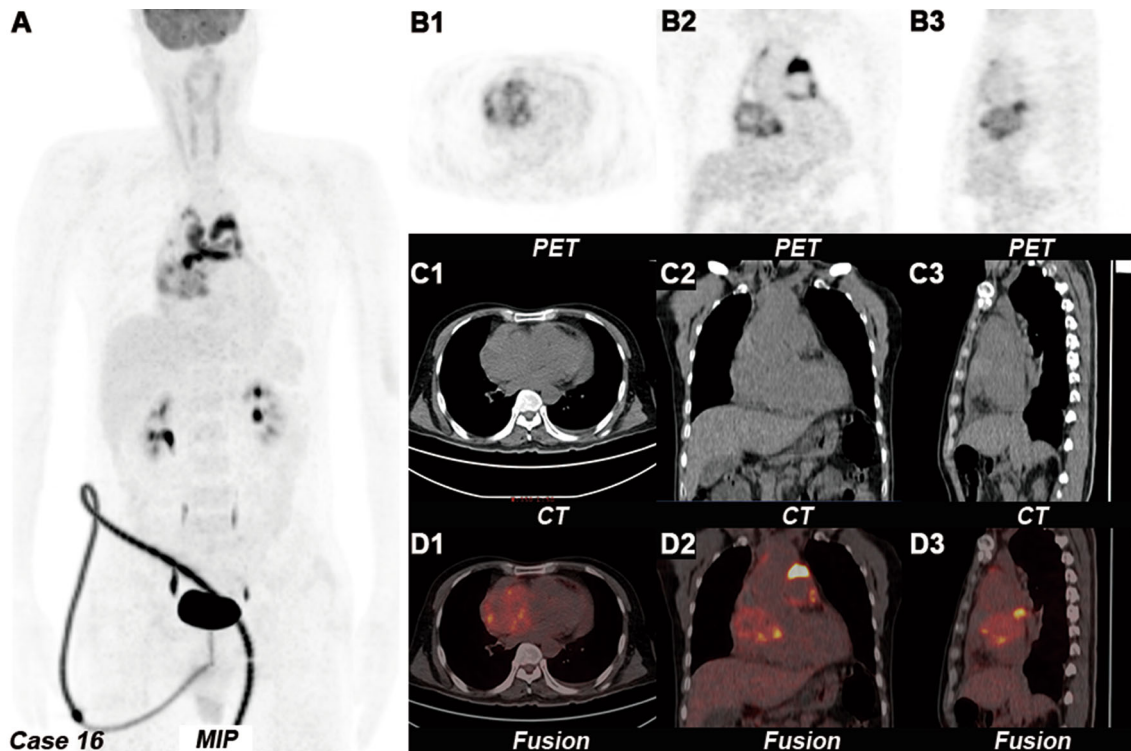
Primary cardiac angiosarcomas in the right atrium. MIP PET image (A), ^{18}F -FDG PET (B), CT (C), and fusion images (D). Transverse (1), coronal (2), and sagittal images (3). A MIP image showing multiple foci of uptake in the heart and mediastinal region. B, C, and D showing an irregular mass with increased uneven ^{18}F -FDG uptake (SUVmax: 14.8) in the right atrium..
